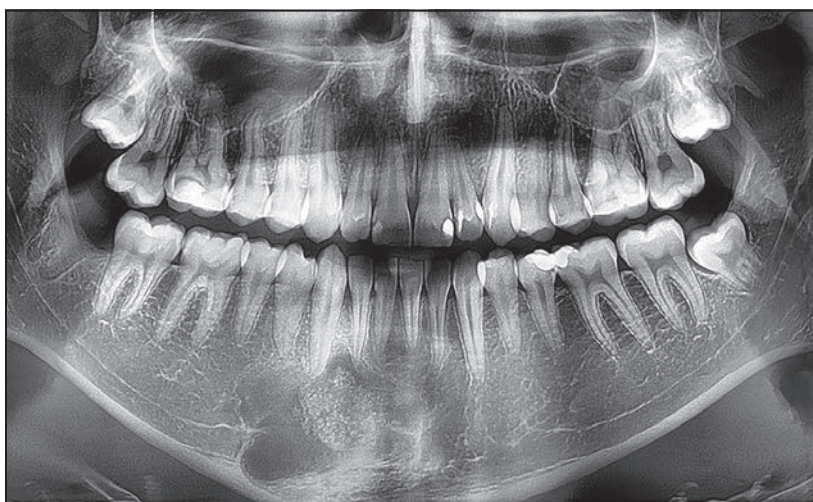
Panoramic radiographic view at 2 months postoperative. Partial bone repair and nonresorbed, dense ADG are still visible.
